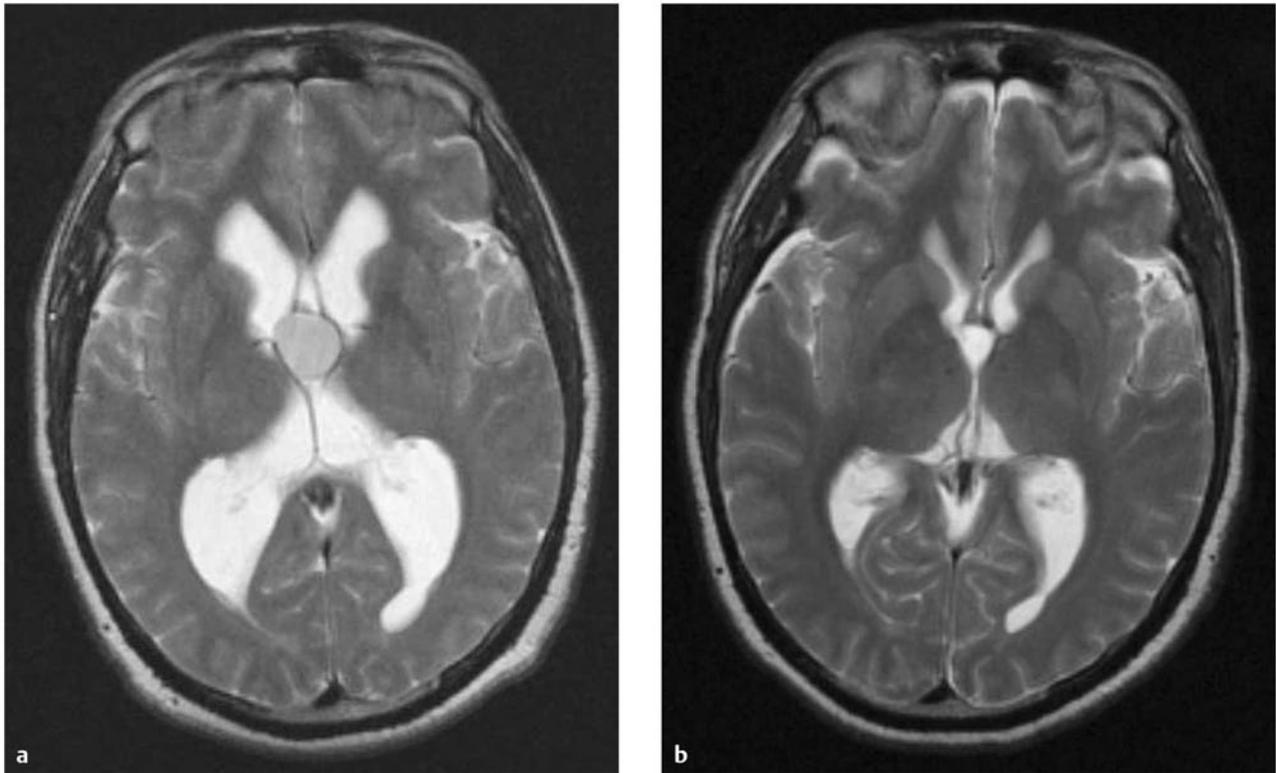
Colloid cyst resection. (a) Axial T2-weighted magnetic resonance (MR) image of a colloid cyst with obstruction at the foramen of Monro and resulting ventriculomegaly in the lateral ventricles. (b) Axial T2-weighted MR image following endoscopic resection of the colloid cyst with a patent foramen of Monro and resolution of the ventriculomegaly.
